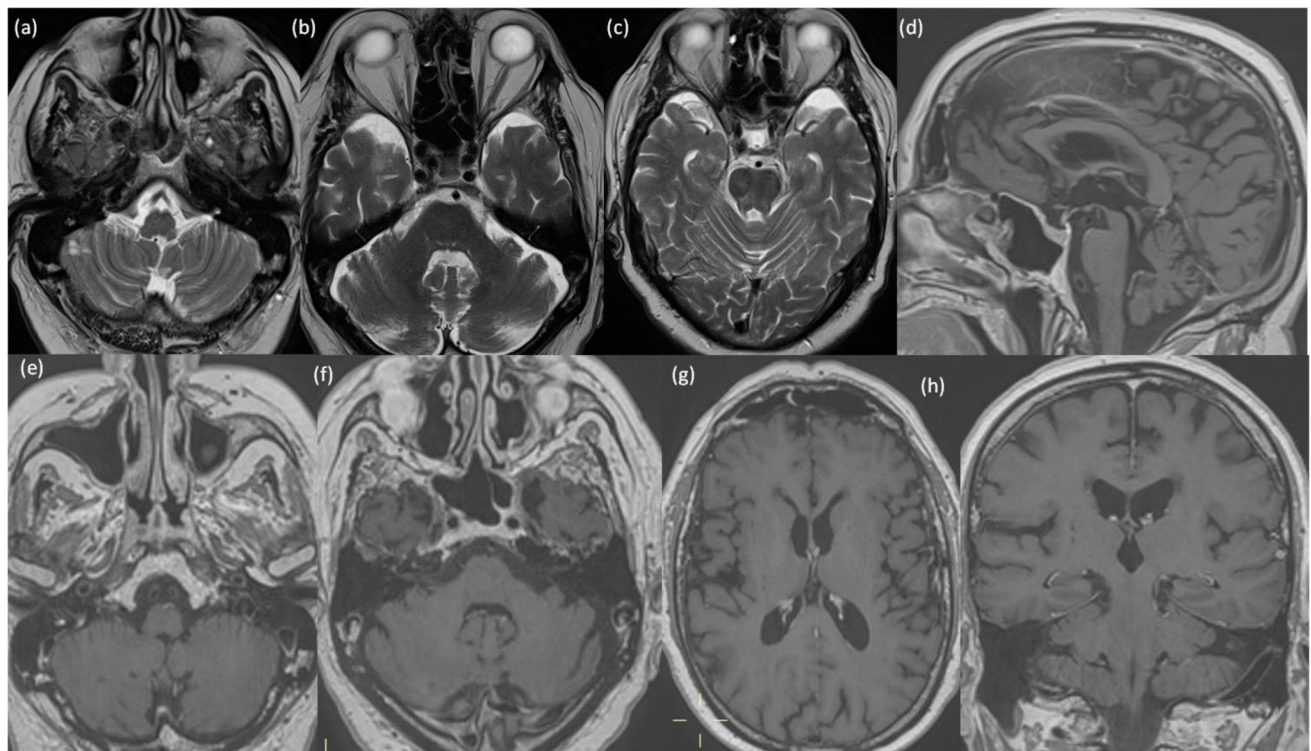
Post treatment MRI after 2 months. T2 axial images through posterior fossa (a-c) and post contrast T1 images (d-h) showing resolution of the changes seen in Figure 3.
